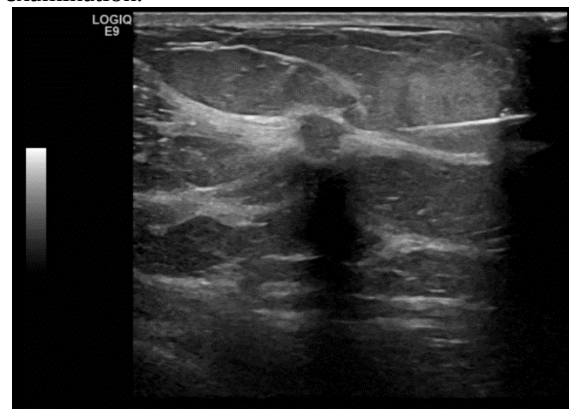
Ultrasound image of a right breast mass.
